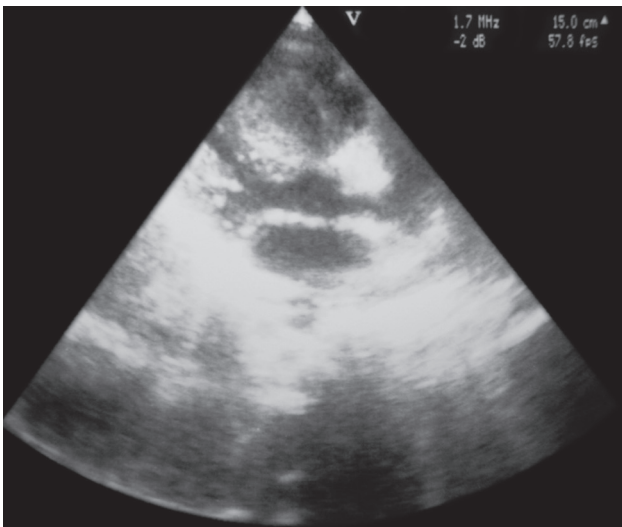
A postoperative echocardiographic view showing a mass-free right ventricle three days after surgery.
